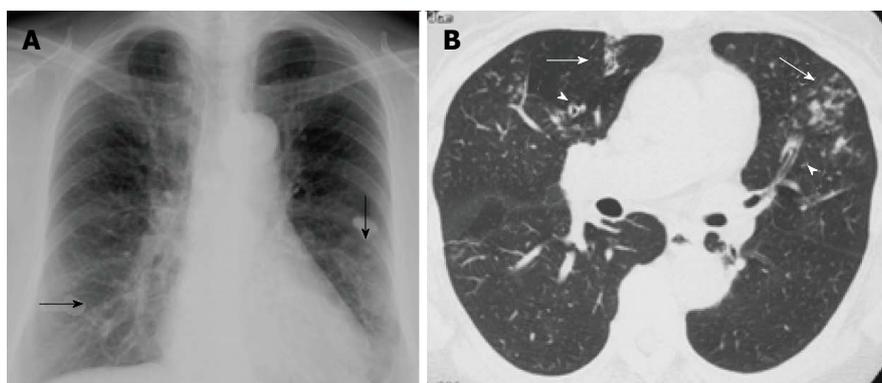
Chlamydomphila pneumoniae* pneumonia showing infectious bronchiolitis in a woman in her 60s. A: Chest radiograph shows faint reticulonodular opacities in both lower lung fields (arrows); B: Thin-section computed tomography reveals centrilobular nodules (arrows) with bronchiectasis (arrow heads) in the middle lobe and lingula.
